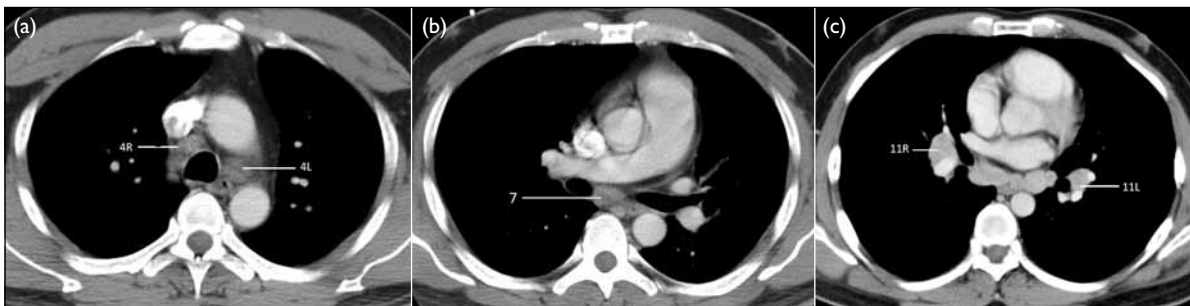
Computed tomographic scans of the typical location of lymph nodes sampled by endobronchial ultrasound-guided transbronchial needle aspiration
